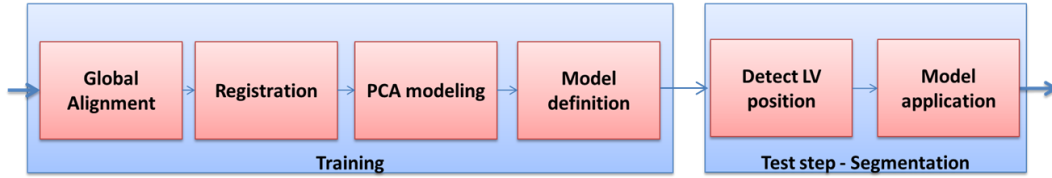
Block scheme for segmentation in t-MRI using the strategy proposed in [80].
